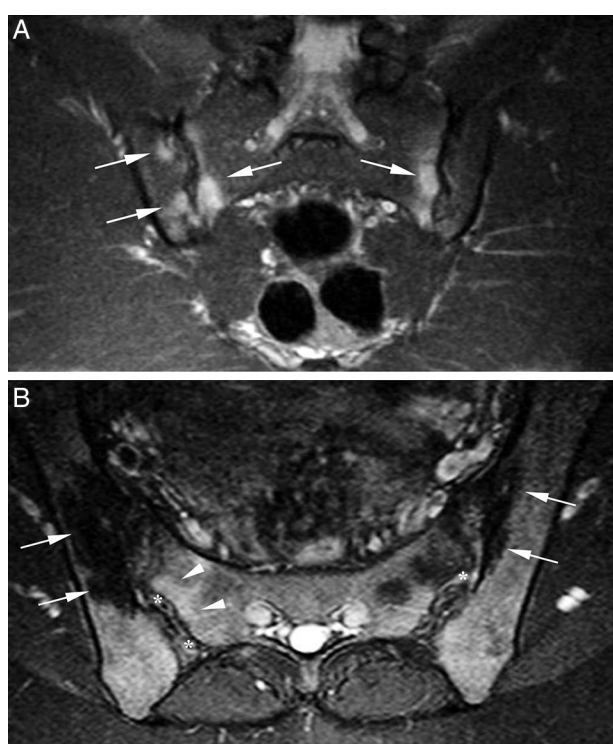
A, T2-weighted coronal MRI image with fat signal saturation, showing bone marrow edema in the upper and middle thirds of sacroiliac joints (arrows); B, T2-weighted axial MRI image with fat signal saturation, showing bone sclerosis in the upper third of sacroiliac joints (arrows). Subchondral edema in the right sacral aspect (arrowheads) and enthesitis in iliac and sacral aspects (asterisks) are found.
